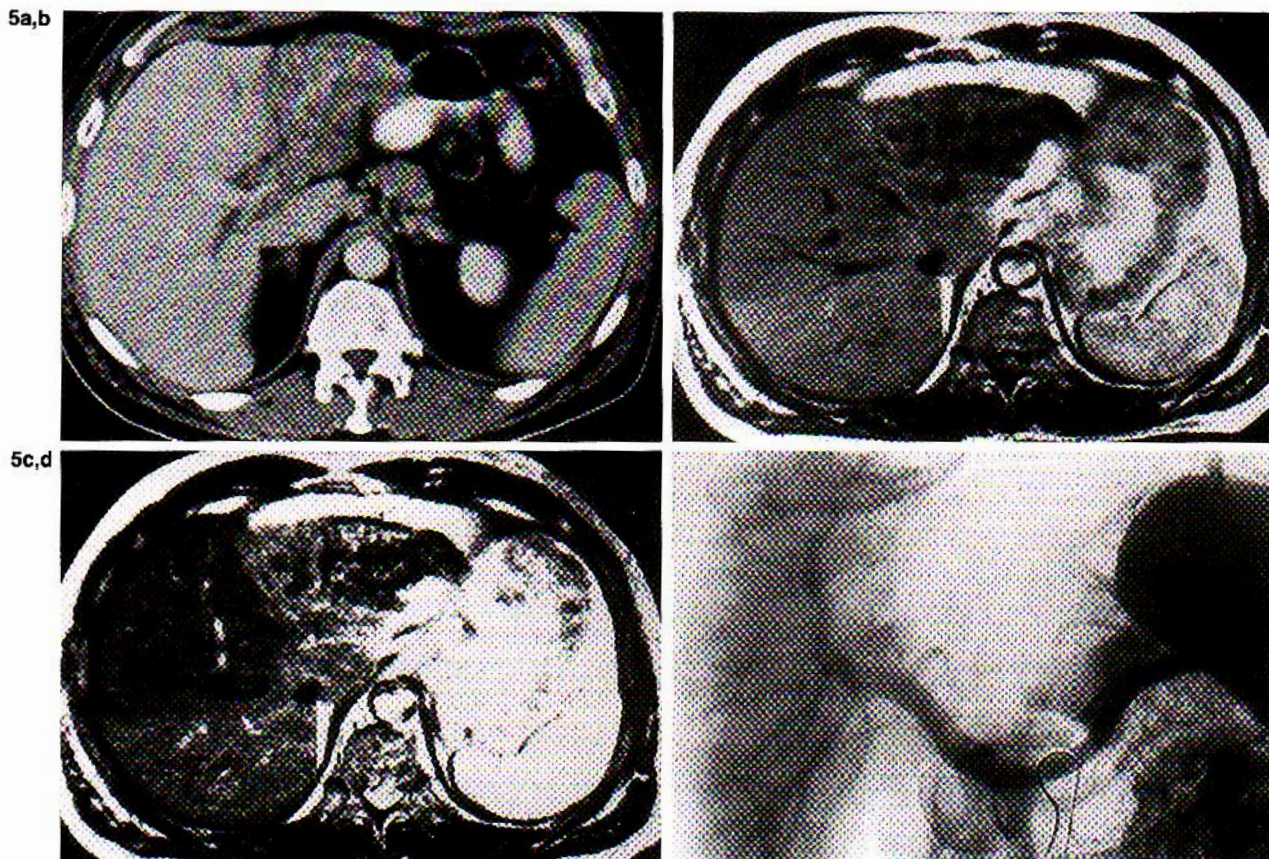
CT scan (a) shows slightly calcified mass in left lobe involving the hilum. T1-weighted (b) (TR 550 ms; TE 26 ms) and T2-weighted (c) (2,000 ms; TE 150 ms) images show low, heterogeneous signal of the fibrous and parasitic mass; low signal in the anterior part and intermediate signal in the posterior part of the right hepatic lobe and caudate lobe. Angiography (d) (portal phase) demonstrates obstruction of the left branch, which explains the asymmetry of the MR signal in the right lobe.
